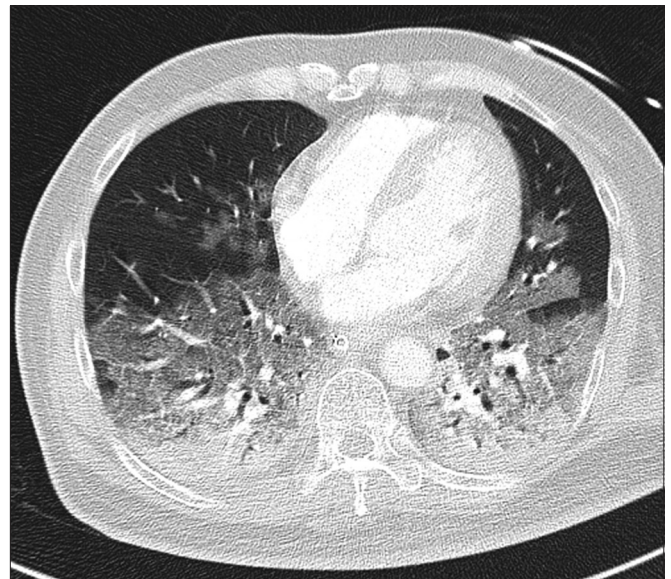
CT image of the thorax shows typical areas of intense parenchymal opacification in the dependent lung and nondependent ground-glass opacification, consistent with acute respiratory distress syndrome.
